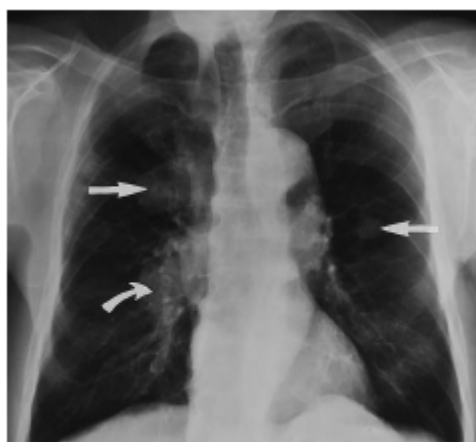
Chest radiograph shows bilateral pulmonary masses (straight arrows) and mediastinal adenopathy (curved arrow) from MCC.
